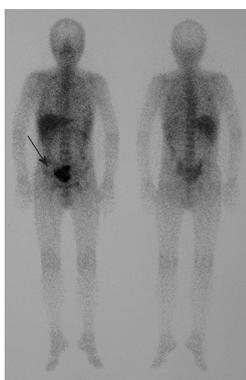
Gallium-67 scintigraphy, showing collection in the pelvis (arrow).
